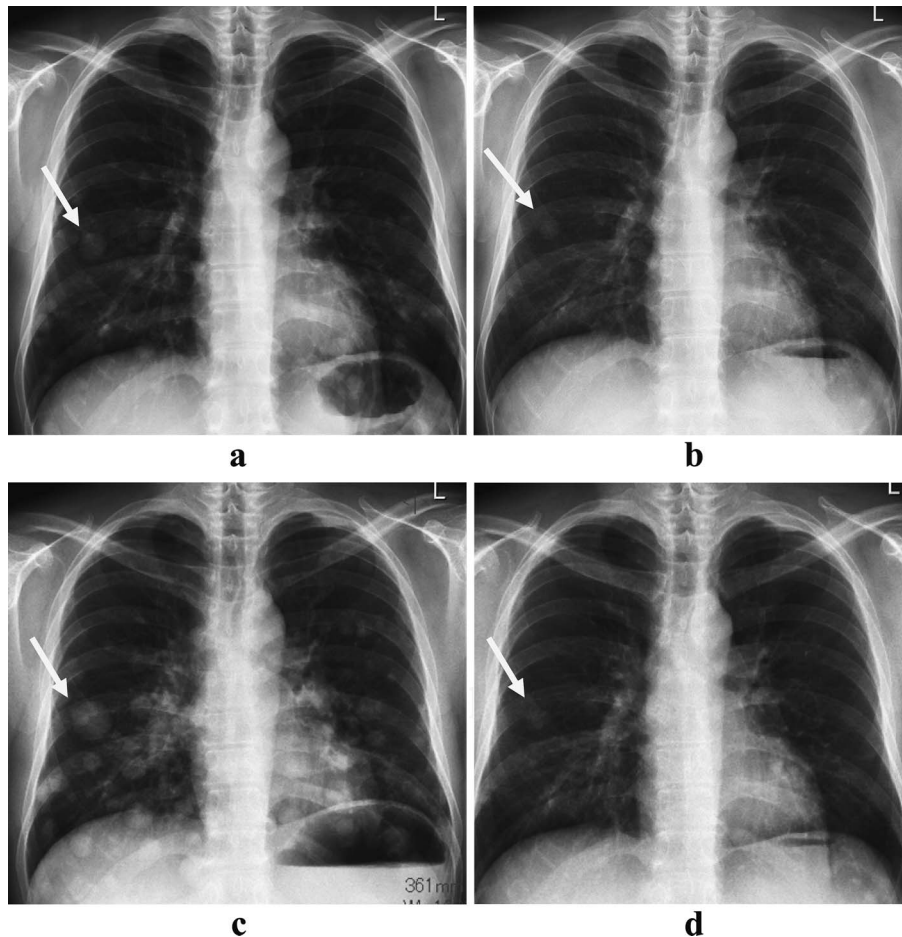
Chest radiography: (a) lung metastases in July 2007; (b) reduction of lung metastases after administration of gemcitabine in August 2007; (c) exacerbation of lung metastases in October 2007; and (d) reduction of lung metastases after 4 weeks of administration of gemcitabine combined with cisplatin in December 2007. Arrows show the maximal nodule of each lung metastasis.
